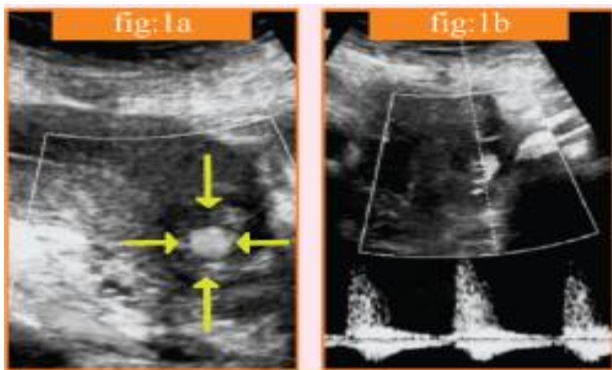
Trans-abdominal USG with colour Doppler
